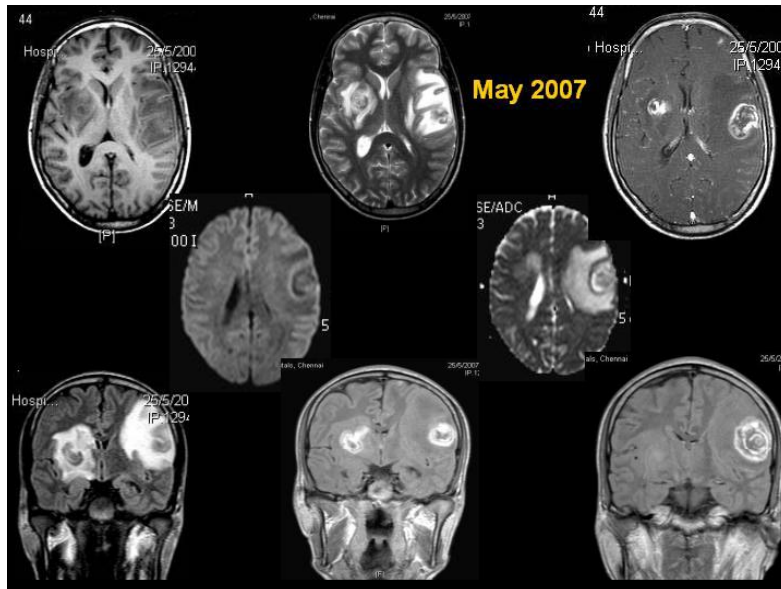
MRI shows multiple, nodular lesions with perilesional edema in both temporal lobes; lesions display multiple concentric layers of enhancement on post contrast study.
